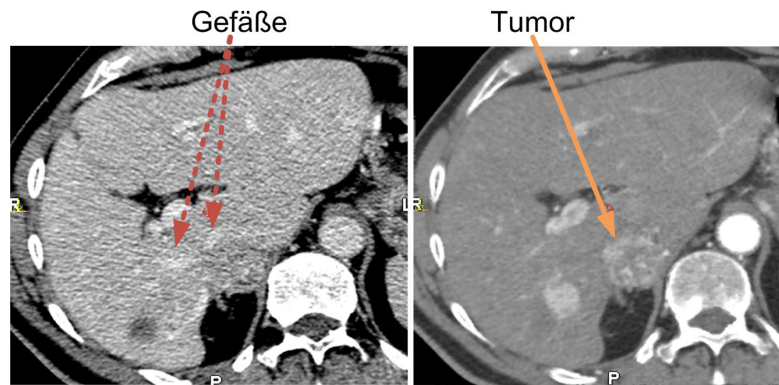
CT-Bilder der Leber zu unterschiedlichen Zeitpunkten der Kontrastmittelaufnahme. In der linken Aufnahme sind zwei Gefäße zu erkennen. In der rechten Aufnahme ist ein Tumor sichtbar.
